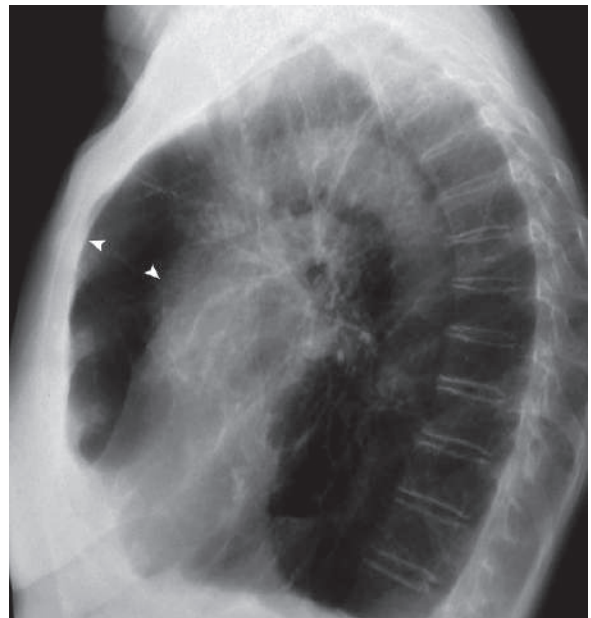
Lateral plain chest radiograph of a patient with congenital α -1 antitrypsin deficiency disease shows increased retrosternal space due to emphysema (arrowheads)
